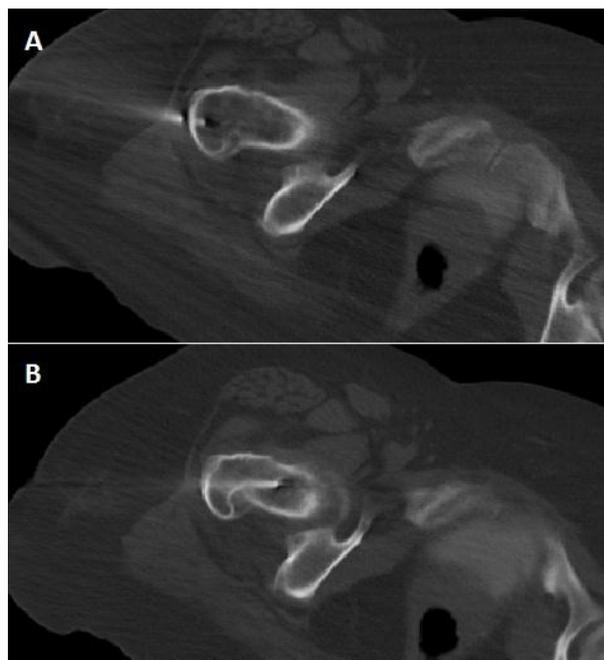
(left): 43 year old female with malignant phyllodes tumor. CT guided bone biopsy. Coaxial system of bone needles advanced under CT guidance into the intertrochanteric region where the permeative pattern was best visualized.
